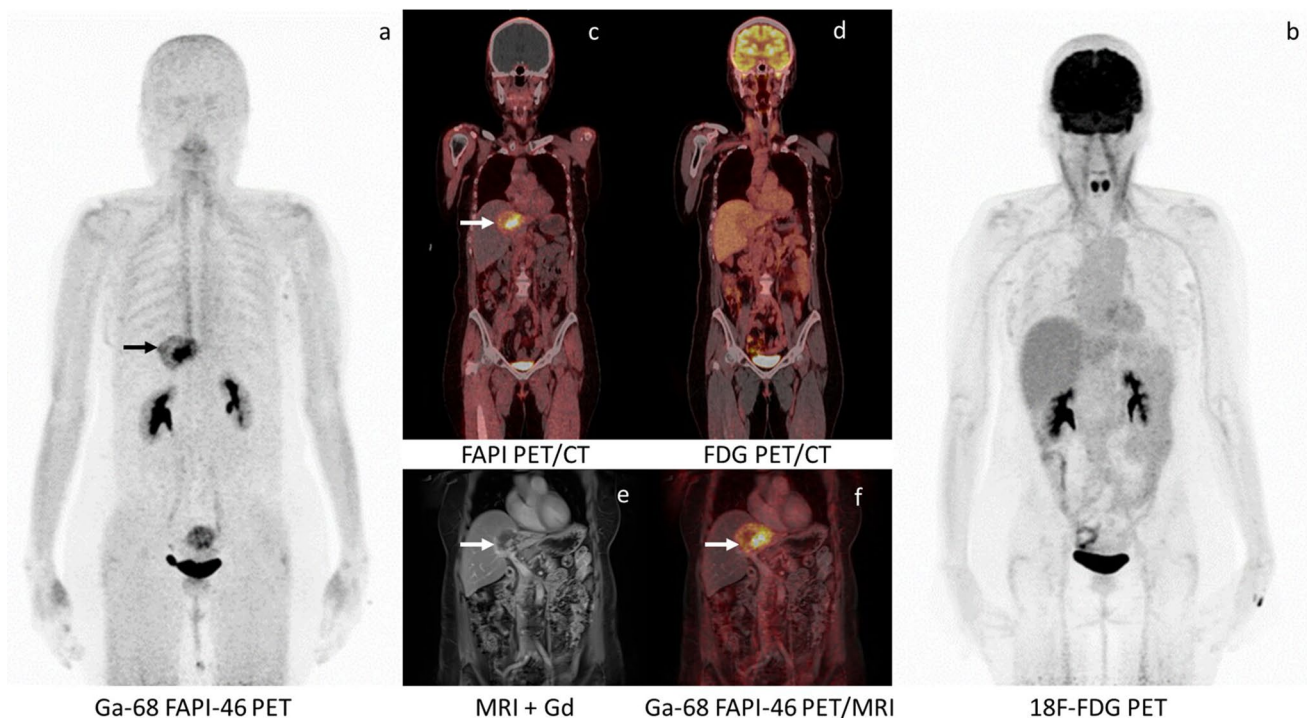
Images from a 66-year-old woman with cholangiocarcinoma who underwent chemotherapy (last session approximately 3 months prior to imaging). The patient underwent PET/CT with dedicated liver PET/MRI for restaging. (a) [⁶⁸Ga]Ga-FAPI-46 PET MIP image; (c) coronal fused [⁶⁸Ga]Ga-FAPI-46 PET/CT image; (e) coronal delayed gadolinium-enhanced MRI; (f) coronal fused [⁶⁸Ga]Ga-FAPI-46 PET/MRI image. [⁶⁸Ga]Ga-FAPI-46 PET/CT images show a liver mass (arrow) with intense uptake corresponding to a peripheral gradually enhancing mass involving hepatic segments II, III, and IV on PET/MRI. (b) FDG PET MIP image and (d) coronal fused [¹⁸F]FDG PET/CT do not show the residual viable tumour, which affected this patient's management.
